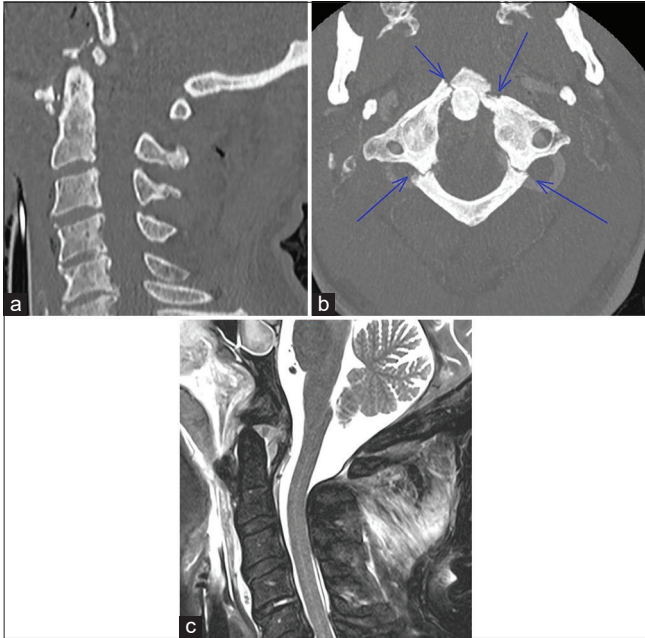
(a) Sagittal bone CT sequence showing anterior dislocation of C2, with a basion density interval of 16 mm and multifragmented fracture of the anterior C1 arc. (b) Axial bone CT sequence showing a Jefferson fracture of C1: bilateral fracture of the anterior and posterior arcs pointed by the blue arrows. (c) Sagittal T2-weighted MRI sequence showing the anterior dislocation of C2 associated with prevertebral hematoma and suspicion of pharyngeal perforation from the anterior arc fragments.
